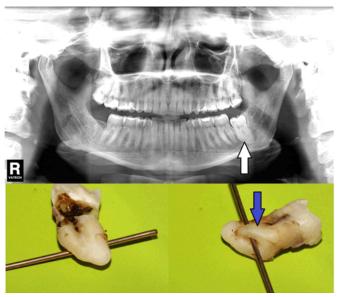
Dark band is seen on the roots in the panoramic radiograph (white arrow). After tooth removal, the metal wire represents the suspected course of the inferior alveolar neurovascular bundle. The lingual root and its nerve-surrounding conformation (blue arrow) could be detected on cone-beam computed tomography scan image, with the possible modification of the removal to coronectomy.
